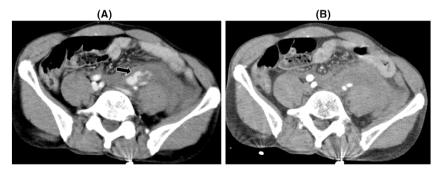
(A) Computed tomography showed the left retroperitoneal hematoma and the left common iliac vein injury with venous extravasation (arrow). (B) The iliac artery was intact.
